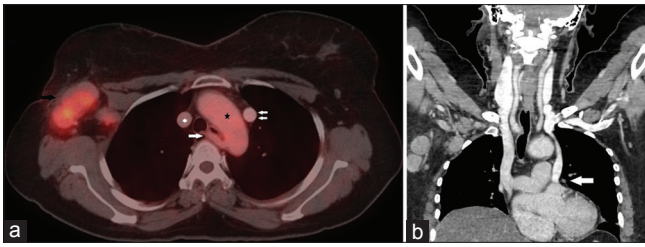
(a) Axial positron emission tomography-computed tomography image shows metabolically active solitary enlarged metastatic right axillary node (black single arrow), well-formed aortic arch on the left side (black asterisk), origin of aberrant right subclavian artery as the last branch of aortic arch and its retroesophageal course (white single arrow). It also shows the left-sided superior vena cava anterior and to the left of the aortic arch (white double arrow). The right-sided superior vena cava is seen in its usual position (white asterisk). (b) Left superior vena cava runs adjacent to the left atrium before turning medially and draining into coronary sinus (white arrow)
